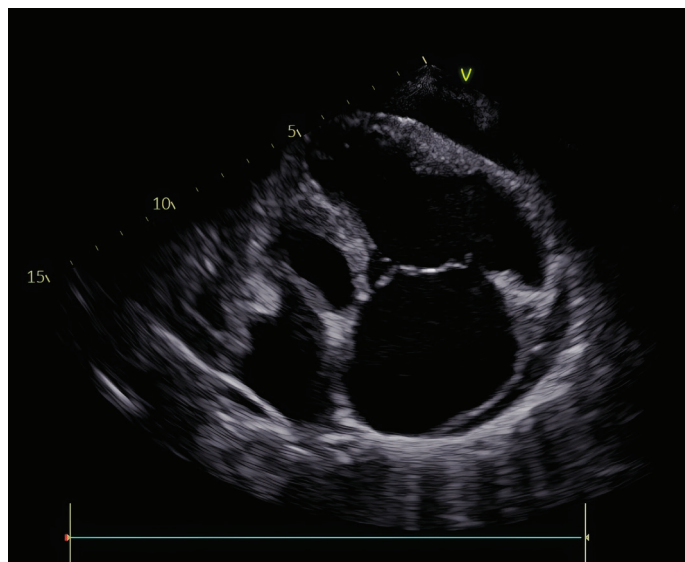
Expansion in the apical 4-chamber view and pericardial effusion in echocardiography.
